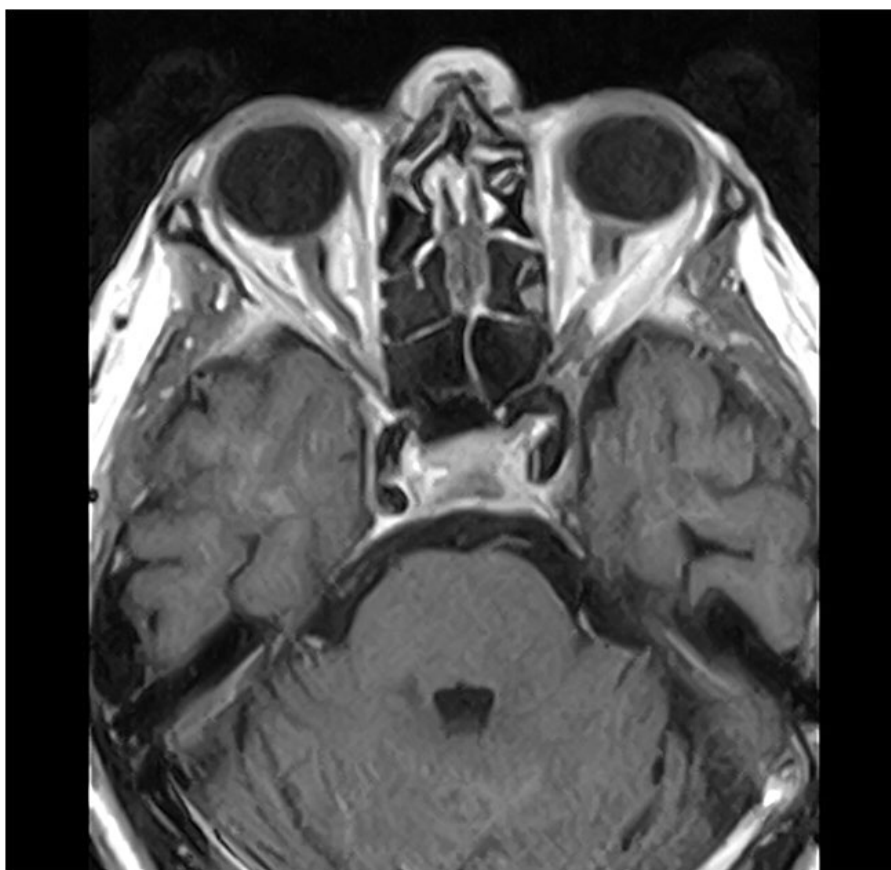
Magnetic resonance imaging (T1 sequence) showing unspecified signal enhancement of the posterior region of the left ocular globe, affecting the optic nerve head
